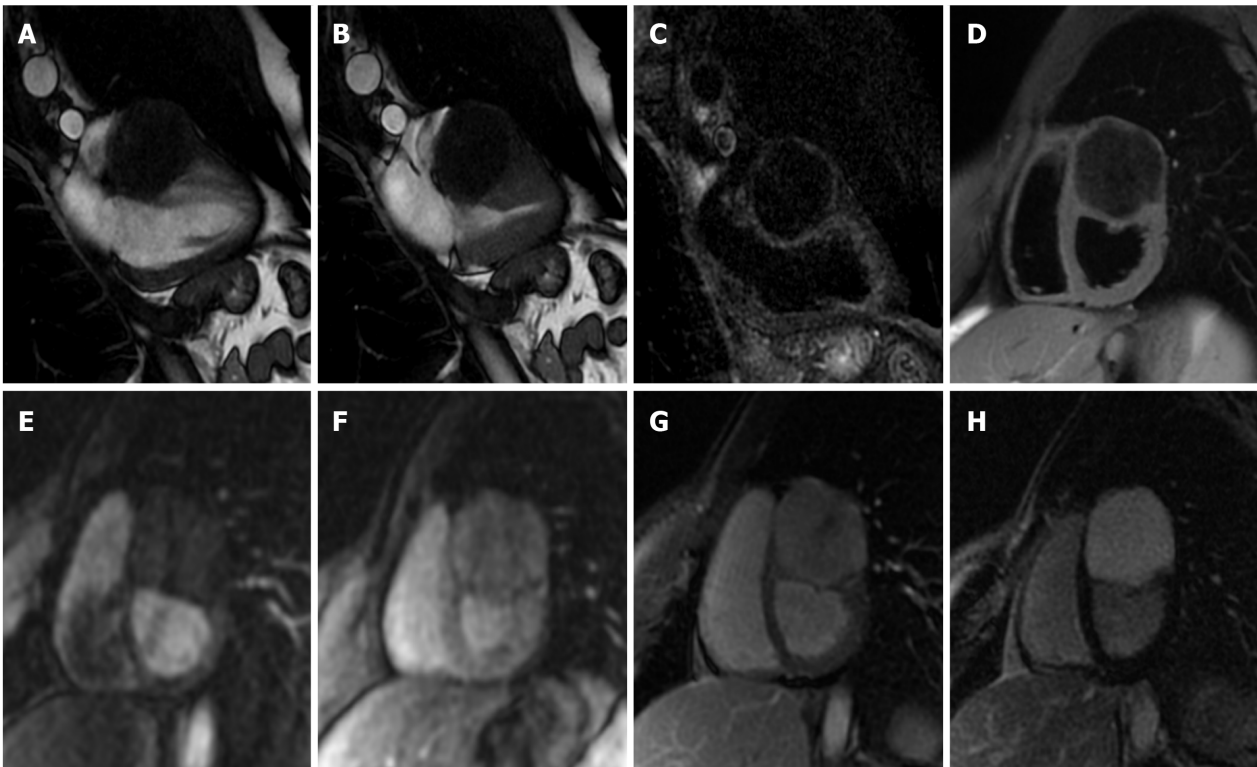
Seventy-one-year-old female with incidental finding of cardiac mass adherent to the septal leaflet of the tricuspid valve on cardiovascular magnetic resonance. The examination was performed for suspected noncompact myocardium on a previous ultrasound examination in a patient with known metastatic thyroid cancer. Orange arrow shows a mobile “valvular” mass at cine-steady state free precession (SSFP) imaging (A and B), with intermediate signal on T1-weighted images (C), high signal on T2 short tau inversion recovery images (D) and with poor enhancement at late gadolinium enhancement (LGE) images (E and F). This location of the mass and its cardiovascular magnetic resonance (CMR) features are in keeping with fibroelastoma. The patient underwent a periodic CMR follow-up for 3 years (G: cine-SSFP and H: LGE sequences), and the mass shows no change.
